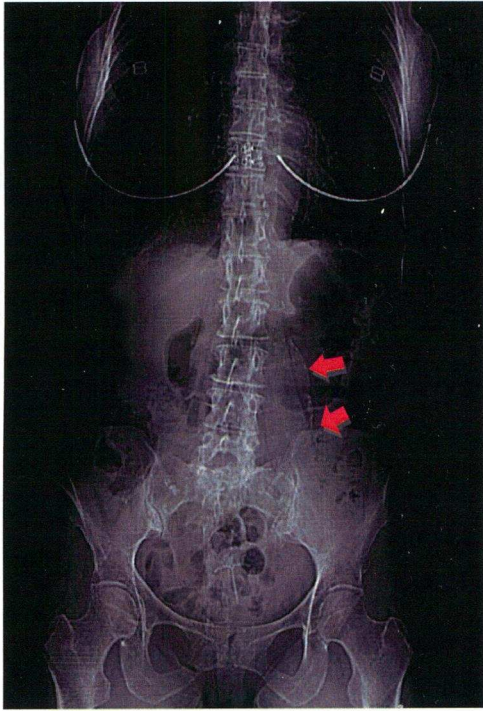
Antero-posterior plain abdominal pelvis X-ray showing: Curvilinear rim of discontinuous calcification in the wall of an AAA (two red arrows); maximum transverse diameter 7.5 cm.
